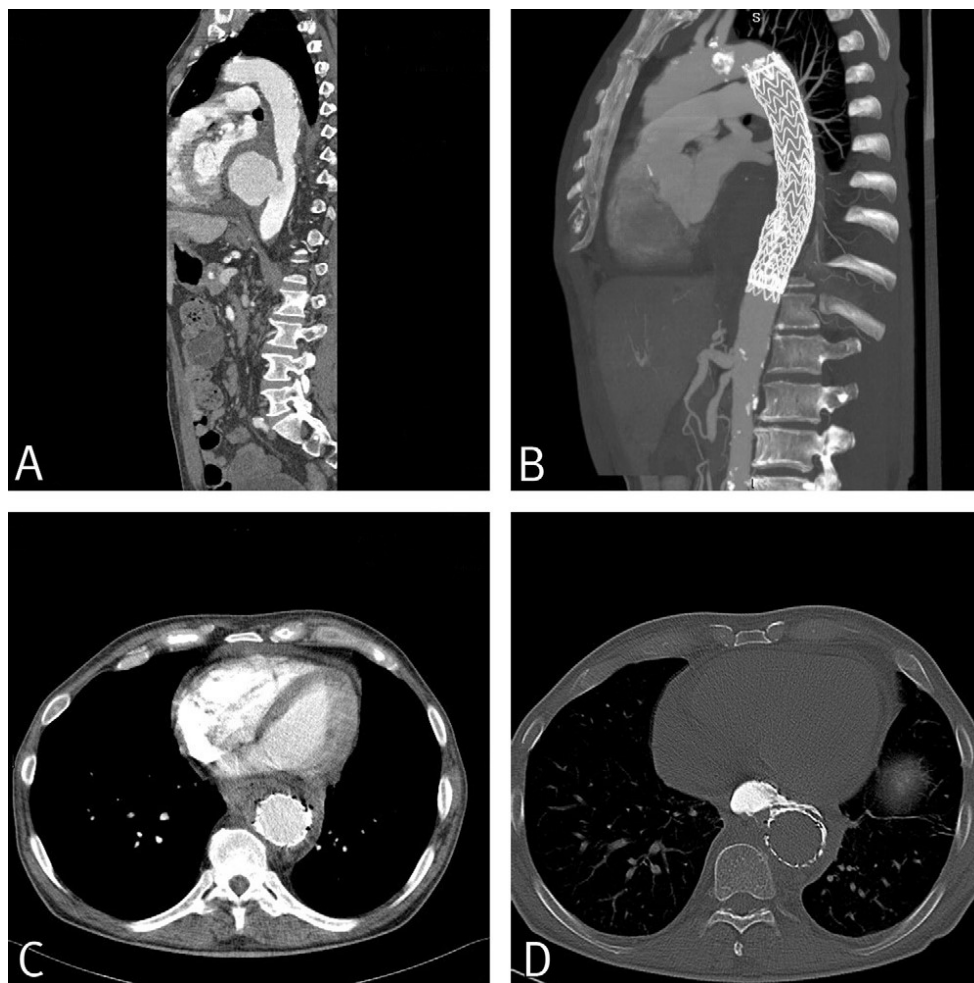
Pre- (A) and postoperative computed tomography angiography (CTA) showing a successful exclusion (B) of a penetrating aortic ulcer with a large pseudoaneurysm but stent graft infection (C) and evidence of an aorto-esophageal fistula (D).
